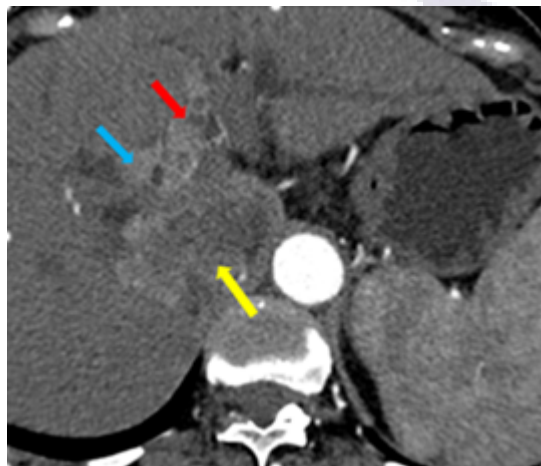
Type IV bismuth classification: Axial CT arterial phase image showing heterogeneously enhancing intraductal growing type of tumour extending beyond primary confluence into right (blue arrow) and left (red arrow) hepatic ducts. Extension into the adjacent liver parenchyma also seen (yellow arrow).
